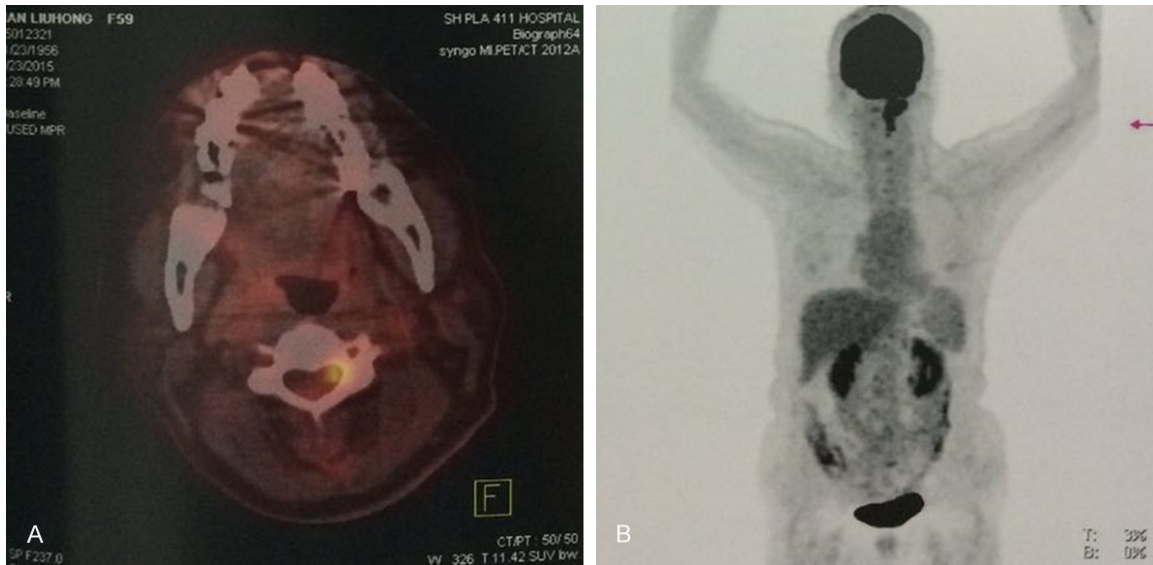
Positron emission tomography-computed tomography showed C2-3 intraspinal mass. A: Elevated fluorodeoxyglucose; B: C2-3 intraspinal mass.
